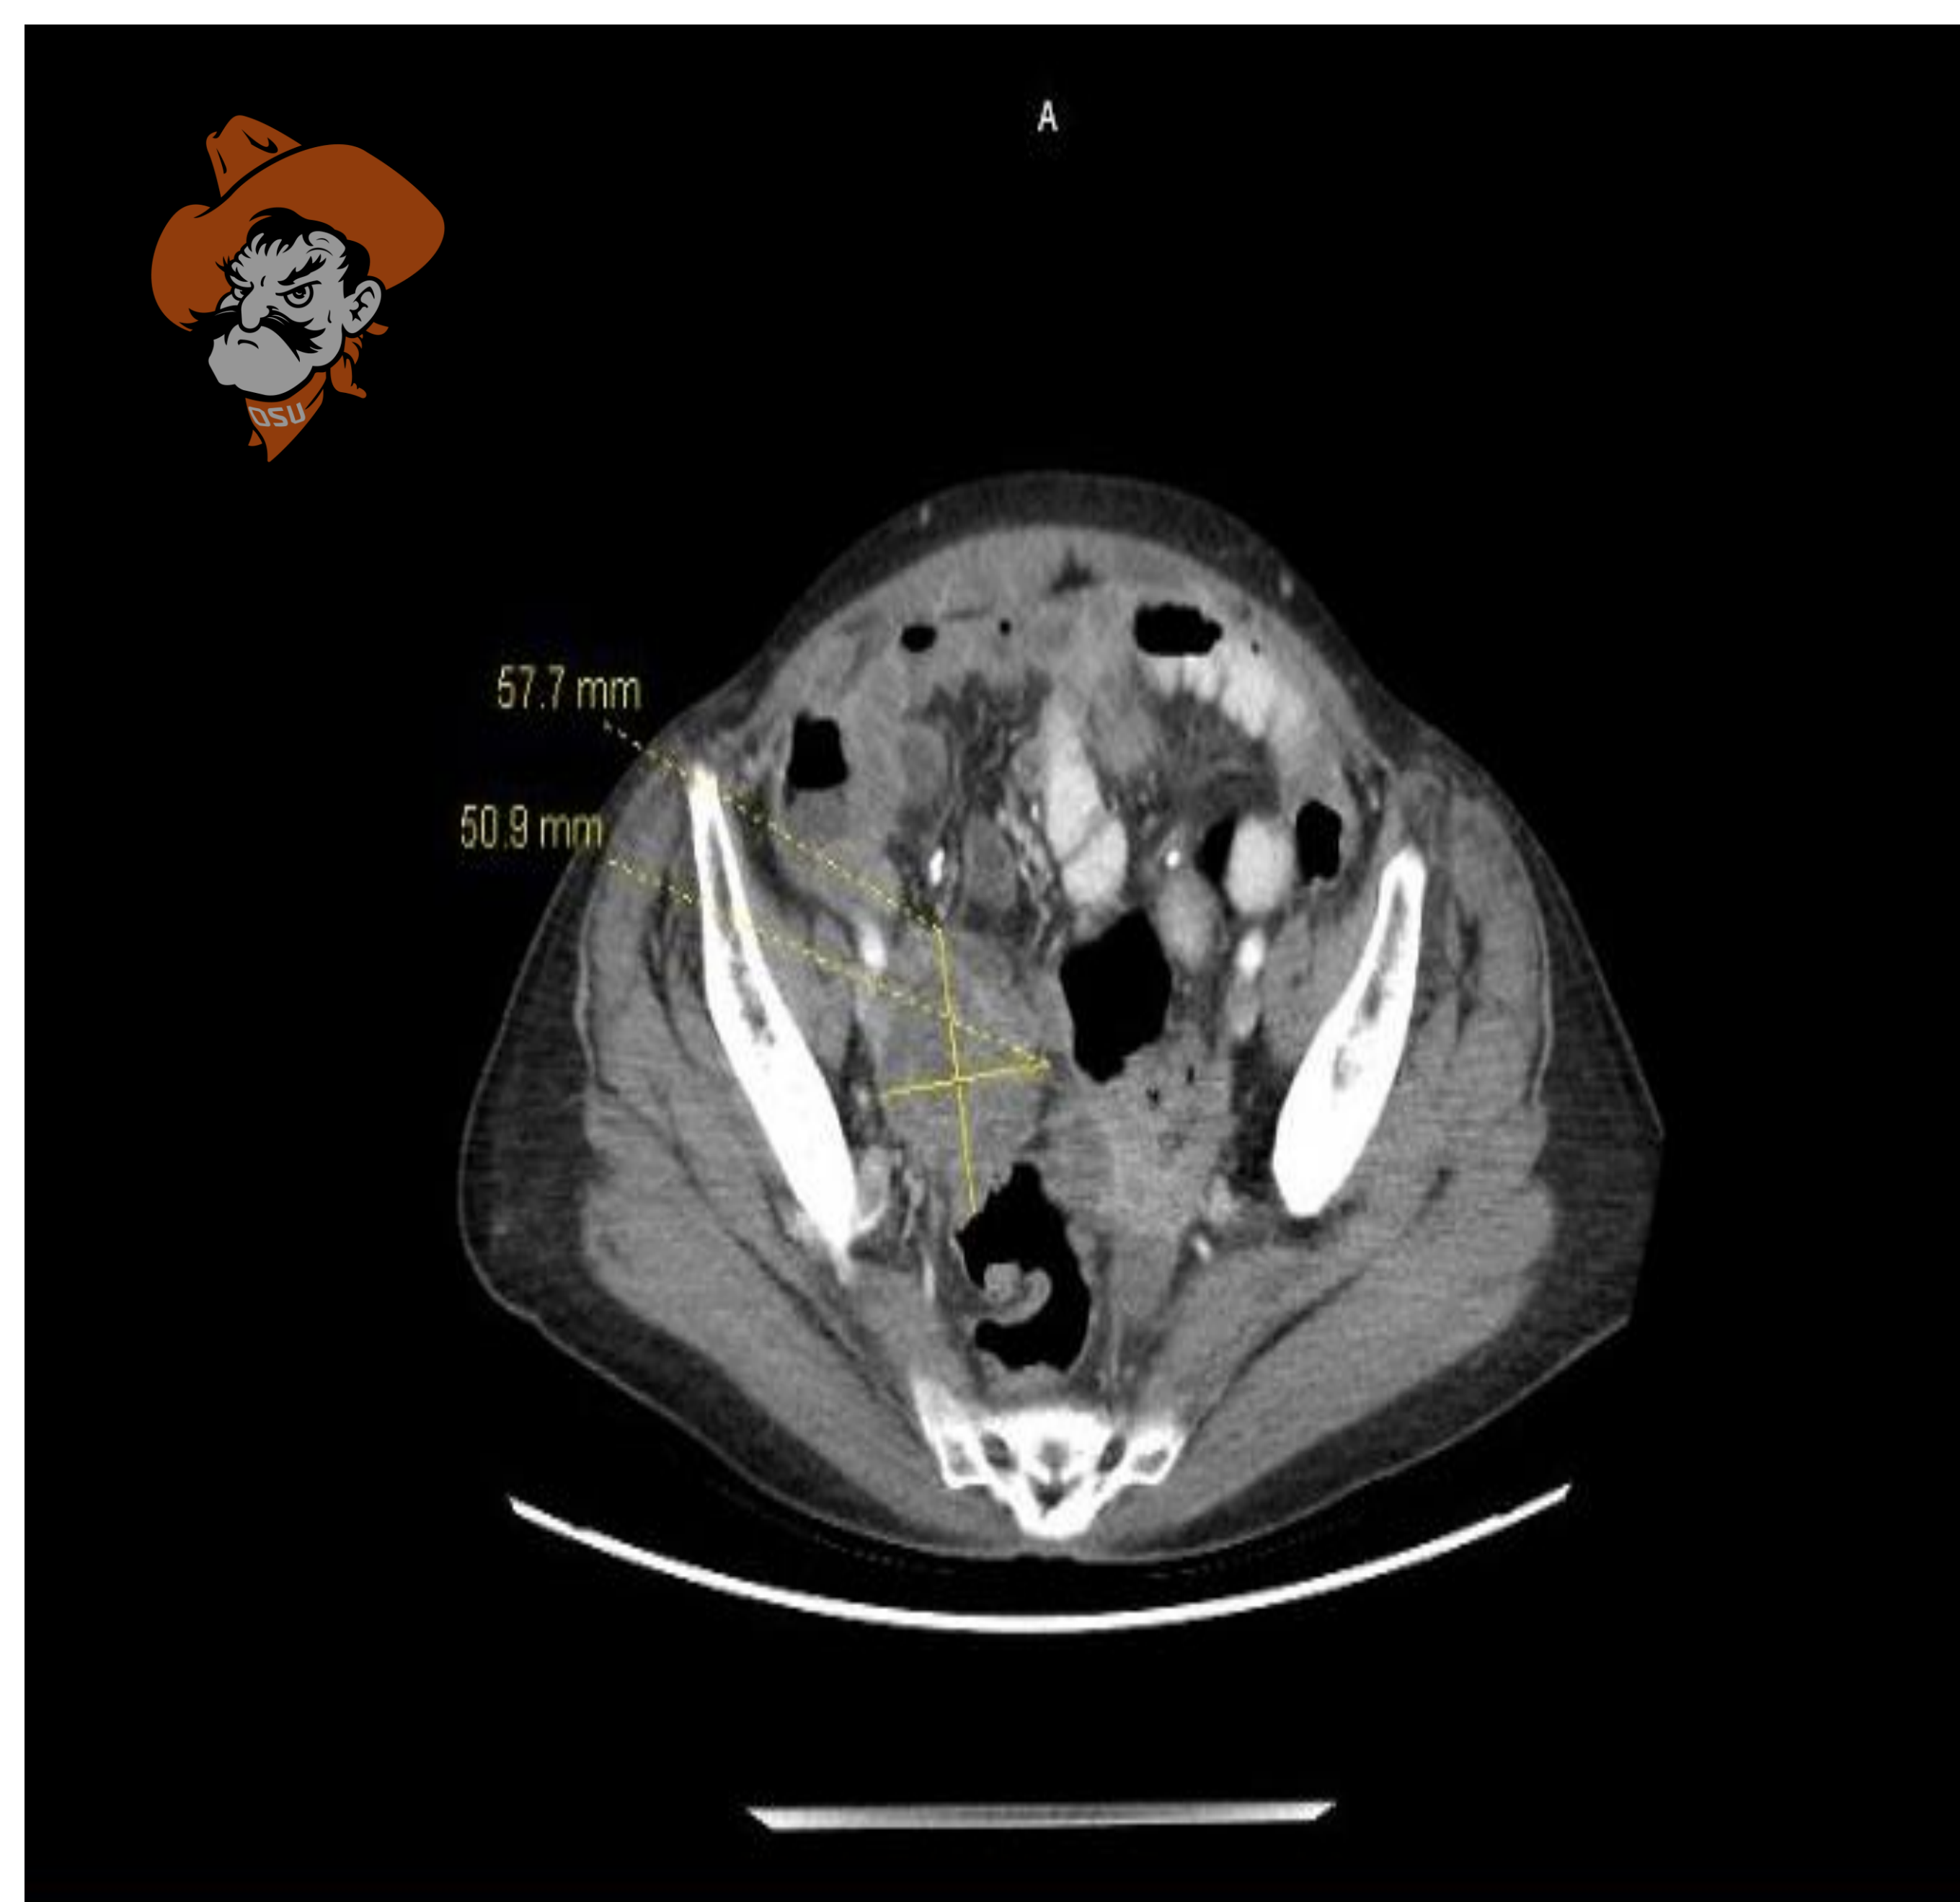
CT Abdomen Pelvis With Contrast- multiseptated cystic right adnexal mass measuring 5.8 x 5.1
